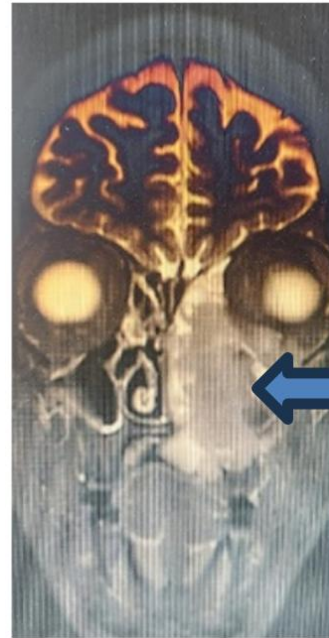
MRI showing lobulated hyperintense lesion in left maxillary sinus, eroding medial and anterior walls of maxillary sinus, extending medially into nasal cavity, with no intracranial extension.
